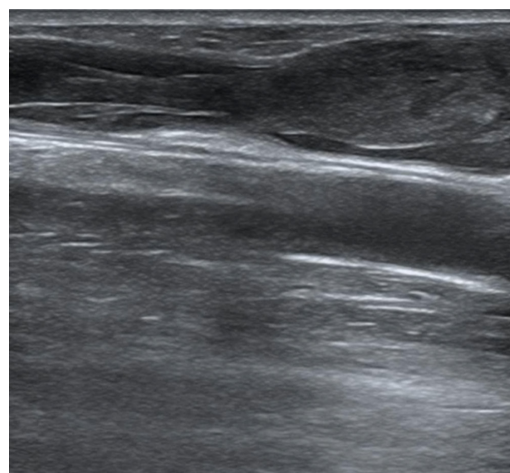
Ultrasound image of the fistula before thrombolysis.
